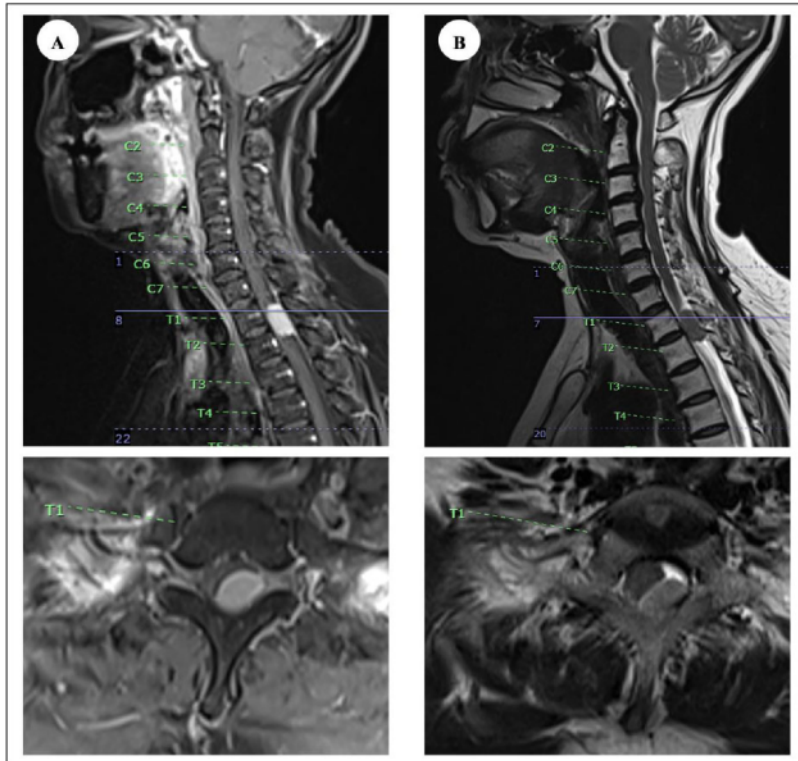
Case 2: Preoperative magnetic resonance imaging of sagittal and axial T1W contrast-enhanced (A) and T2W (B), revealed an intradural extramedullary isointense lesion with well-demarcated, diffuse contrast enhancement of 1.3 x 0.9 x 2.1 cm within the left lateroposterior spinal canal posteriorly at the level of T1-T2, spinal cord driven to the right lateroanterior by the lesion.
